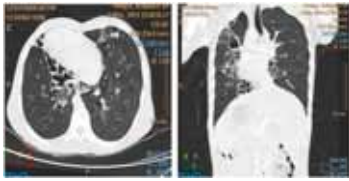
Axial CT lung window showing cystic dilatation of bronchi with thickened wall suggestive of bronchiectasis distributed predominantly in B/L upper lobes and right middle & lower lobes
